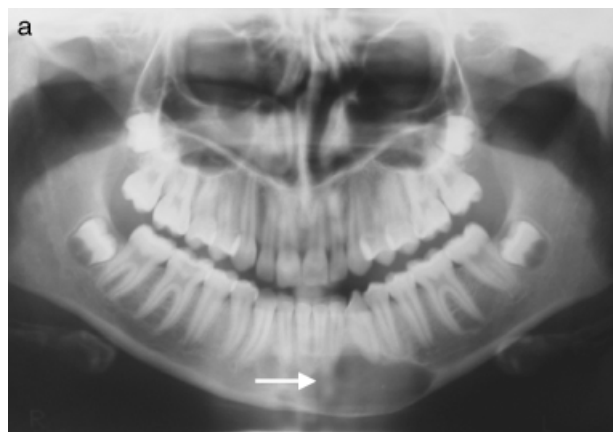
Echographic examination of a traumatic bone cyst of the mandible. (a) Panoramic radiograph showing the wide radiolucent lesion in the anterior mandible. (b) Ultrasound imaging of the same area: it appears as a cystic lesion; the lesion diagnosed as a traumatic bone cyst with sero-sanguinous content.
